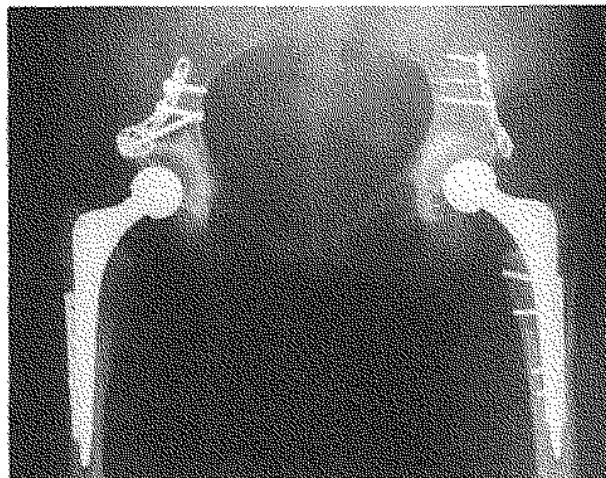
Postoperative radiograph (same patient as fig. 2) with good incorporation of bone graft and without radiolucencies (5 years postoperative).
